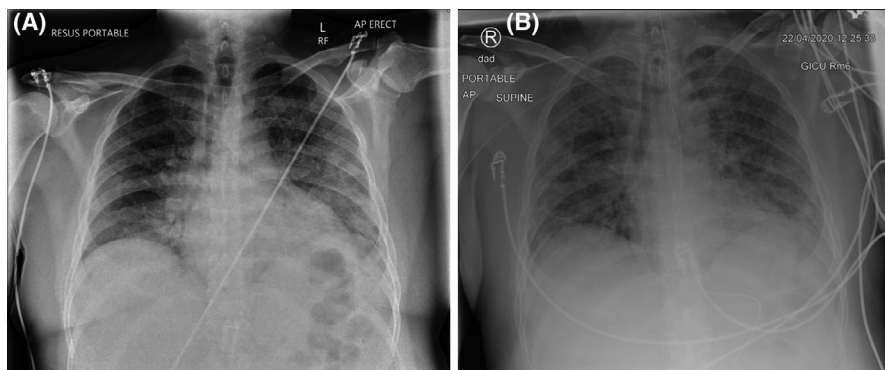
Chest X-Rays (A) on admission showing diffuse airspace shadowing throughout both lung fields more marked on the left with confluent shadowing in the lower zones bilaterally and (B) radiological deterioration on day 23 with more confluent airspace shadowing peripherally in the left lower zone.
